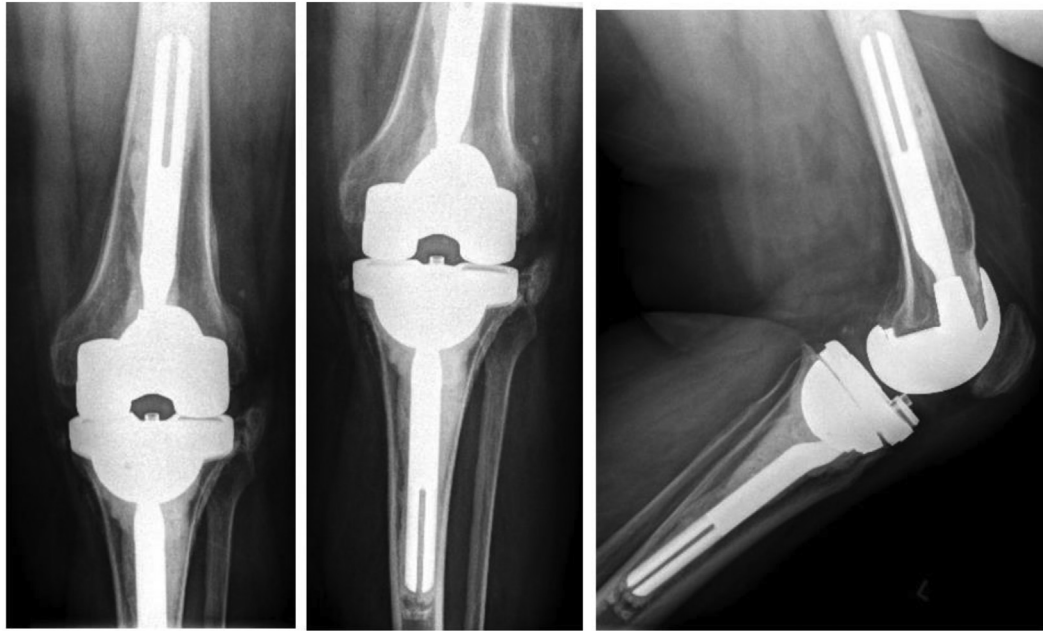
Anteroposterior (left, middle) and lateral (right) radiographs of the patient's left knee at 16 months postoperatively.
